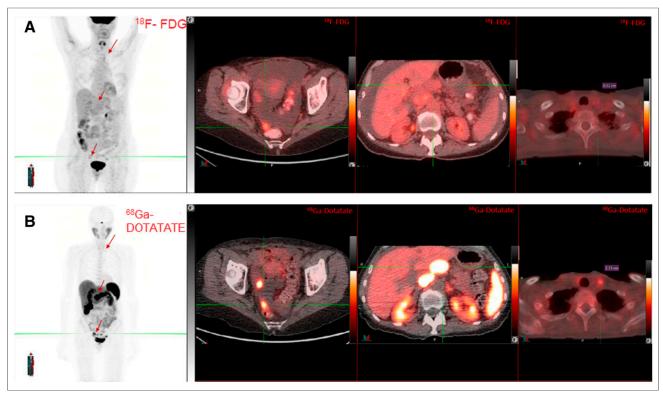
18F-FDG PET/CT (A) and 68Ga-DOTATATE PET/CT (B) in patient with G3 NEN with corresponding cross-sectional imaging.
